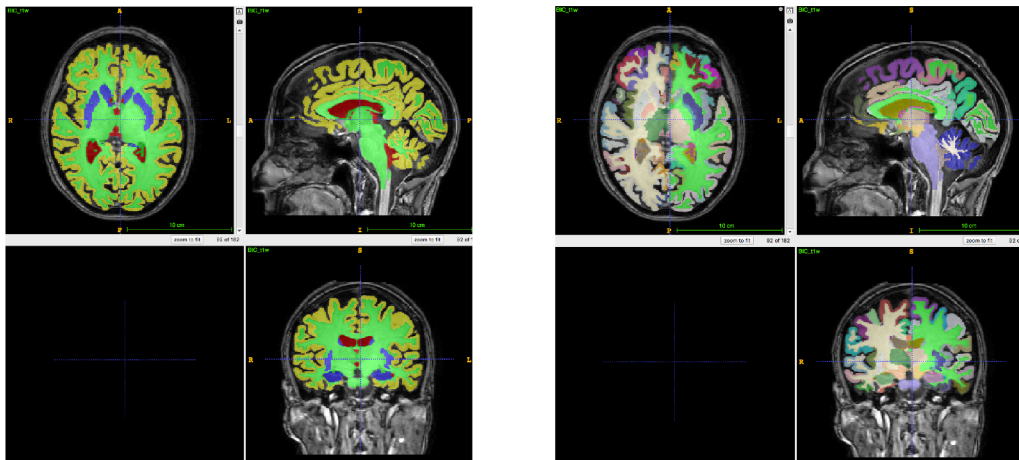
T1-weighted MRI image of a human brain with 4-class segmentation in overlap (left), parcellation of the cortex using freesurfer (right).
